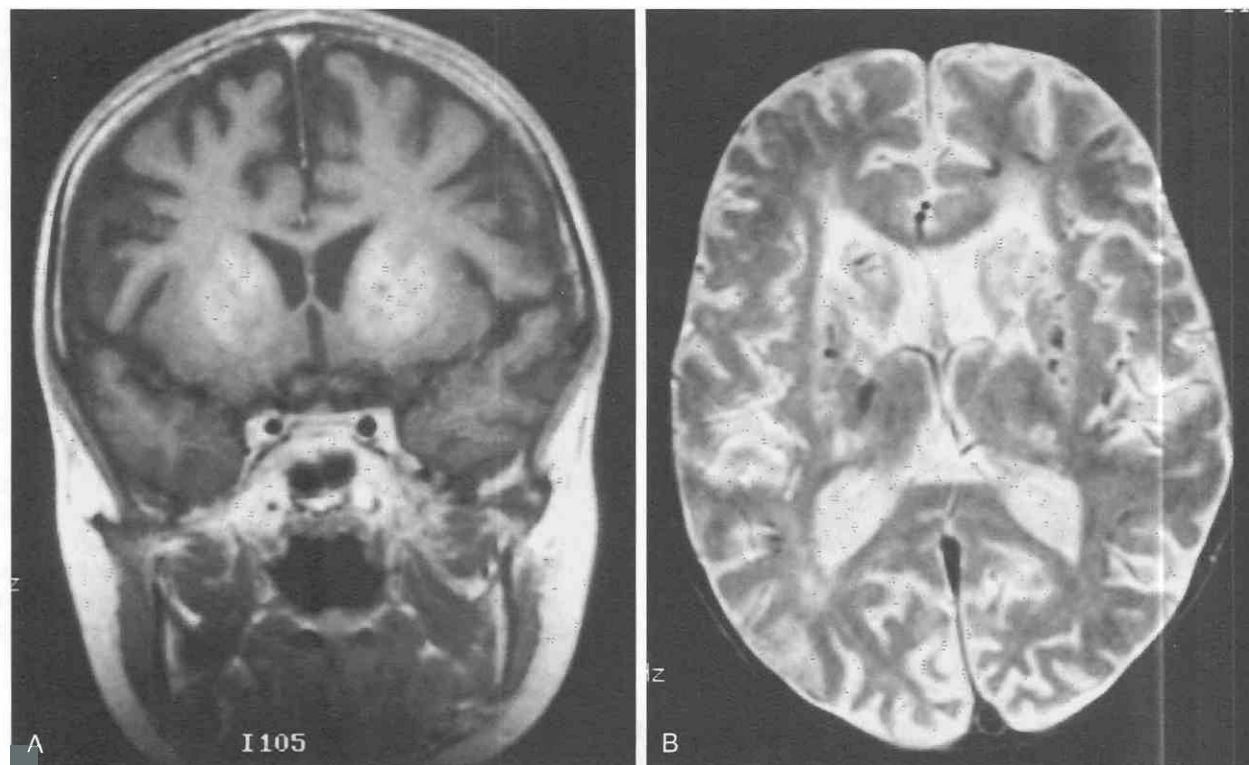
Cockayne's disease in an 11-year-old boy. *A*, T1-weighted coronal MR image demonstrates the prominent basal ganglia hyperintensity, presumably T1 shortening caused by extensive calcification. *B*, T2-weighted axial MR image, with the findings of atrophy, generalized demyelination, and signal dropout in basal ganglia from calcifications.
